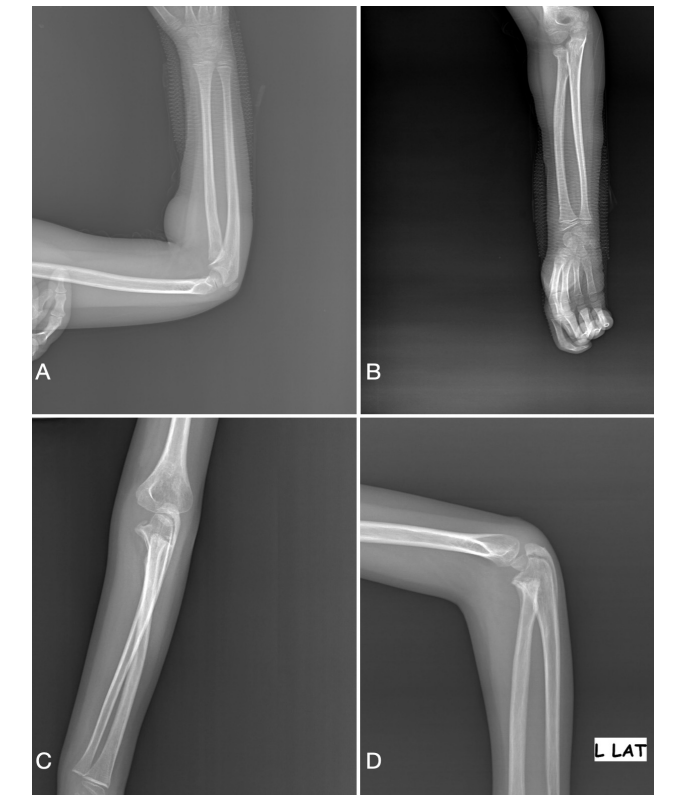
A, B. Radiographic views of 6 months after avascular necrosis of the radius head; C, D. Radiographic views of 1 year after avascular necrosis of the radius head
